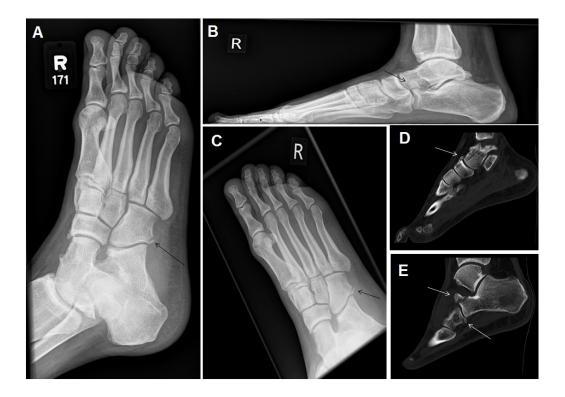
(A) Oblique view of right midfoot plain radiograph showing the missed cuboid bone fracture; (B) Lateral view of right midfoot plain radiograph showing the calcaneal anterior process fracture; (C) Dorsoplantar view of right midfoot plain radiograph showing the cuboid bone fracture; (D) CT sagittal view reconstructed image confirming right calcaneal anterior process fracture and cuboid bone fracture; (E) CT sagittal view reconstructed image showing right navicular bone fracture.
